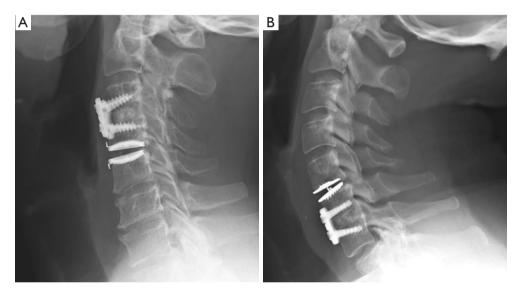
Lateral X-rays showing examples of 2-level hybrid constructs in this cohort: (A) fusion/arthroplasty and (B) arthroplasty/fusion.
